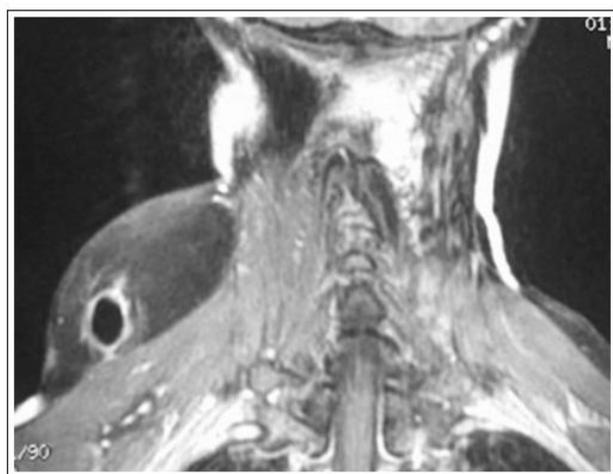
Coronal Fat-saturated T1-weighted image showed multiple prominent thick septa showed enhancement by gadolinium
